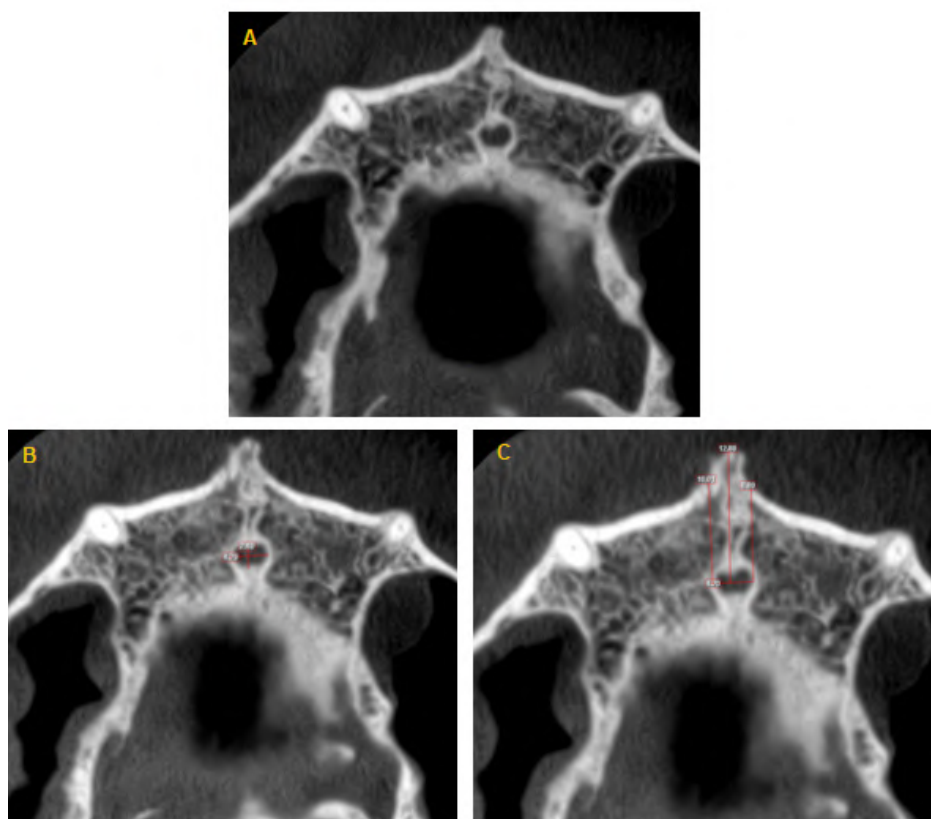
CBCT images of the Stensen foramen (A = Stensen foramen, B = Longitudinal and Transverse diameters of SF, C = Labial Bone Thickness in relation to SF).
